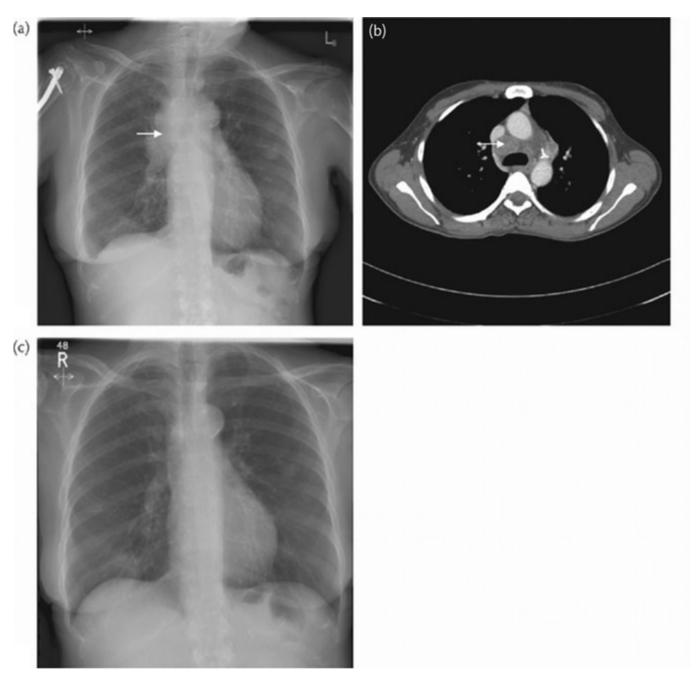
(a) Chest radiograph showing a right upper lobe tumour causing wheeze with bulky right paratracheal nodes (arrow); (b) CT scan of the chest of the same patient as in (a), showing grossly enlarged mediastinal pretracheal lymph nodes (arrow); (c) chest radiograph of the same patient as in (a), showing complete response after two courses of chemotherapy.
